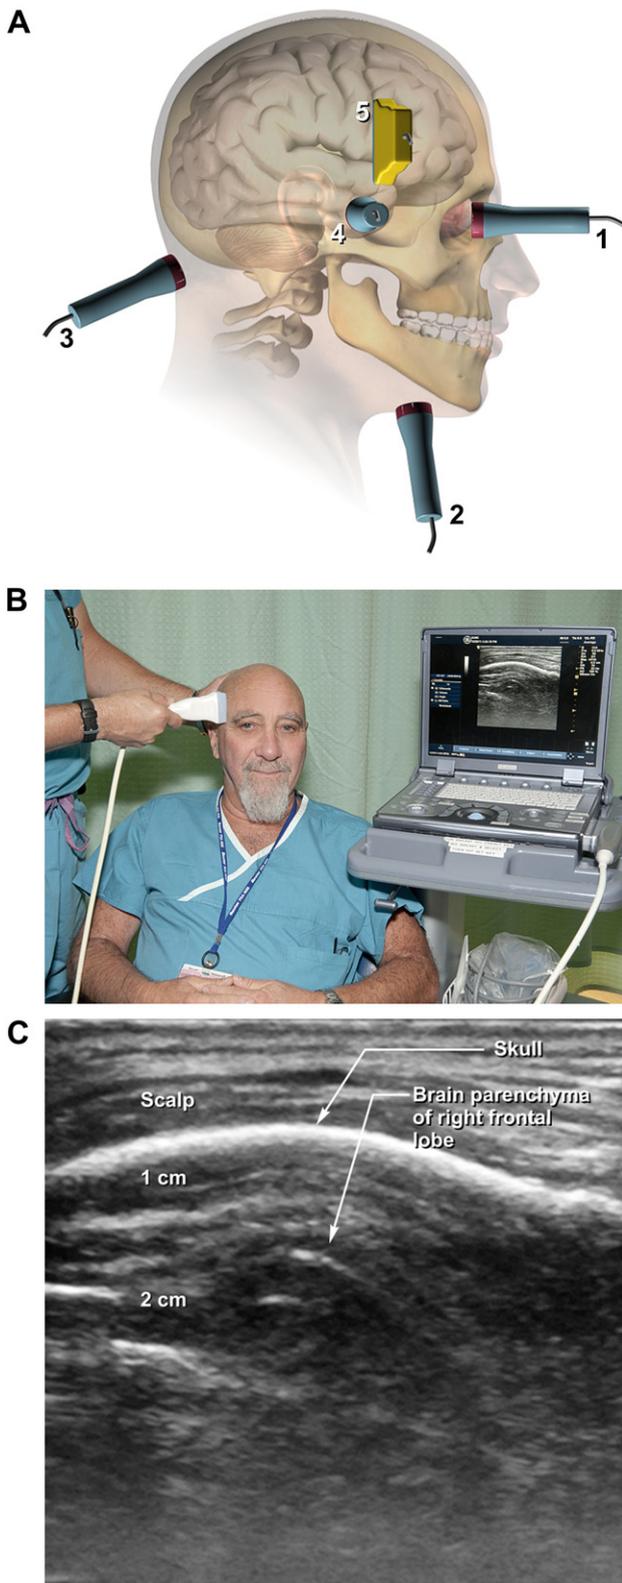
(A) Sites for transcranial ultrasound (TUS). 1–4 are used in Doppler blood flow studies. 1: trans-orbital, 2: sub-mandibular, 3: sub-occipital, 4: temporal window. 5 is the site used in present study, overlying frontal-temporal cortex. (B) Transcranial ultrasound as used in present study (at site 5 in Fig 1A). A 12L-RS probe from a GE LOGIQe ultrasound imaging machine is applied with gel on the scalp overlying frontal-temporal cortex. The image is shown on the monitor of the LOGIQe device. (C) Longitudinal gray scale image from Fig. 1B, typical of images from study participants. Scalp, skull and posterior aspect of right frontal lobe of cerebral cortex are visible, confirming TUS in our study penetrated the skull to reach the brain.
